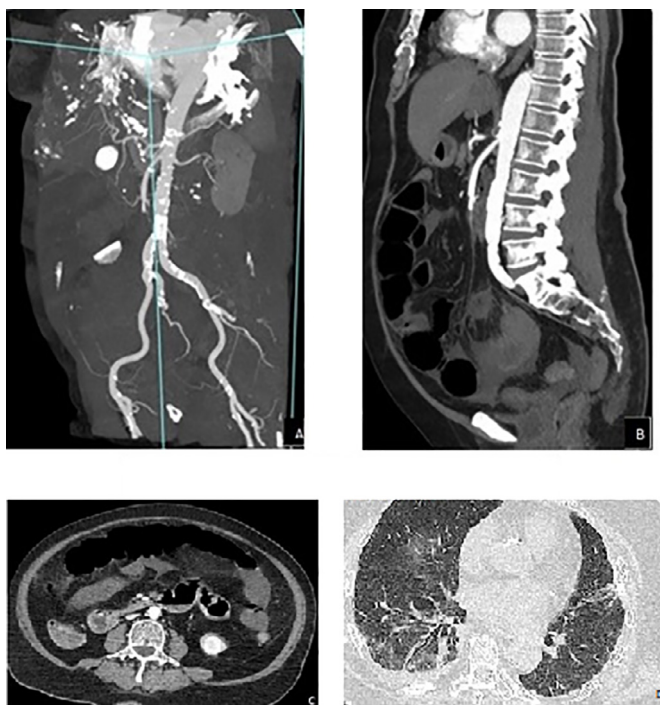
Superior mesenteric artery thrombotic occlusion in its medium segment (a-b). CT scan demonstrates multiple bowel loops dilated containing air-fluid levels and thinning of the walls (c). Thoracic CT-scan (d).
